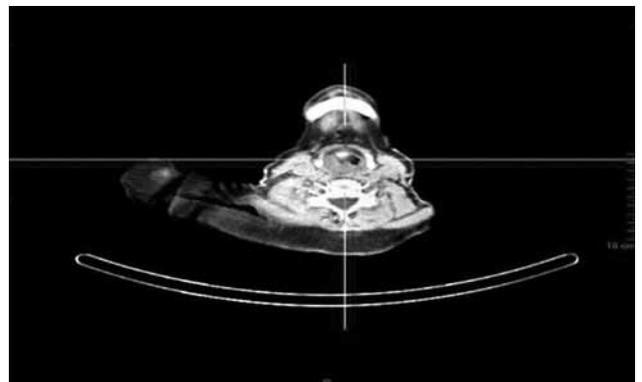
Octreotide-computed tomography scan showing uptake by the tumor located on the right aryepiglottic fold.
